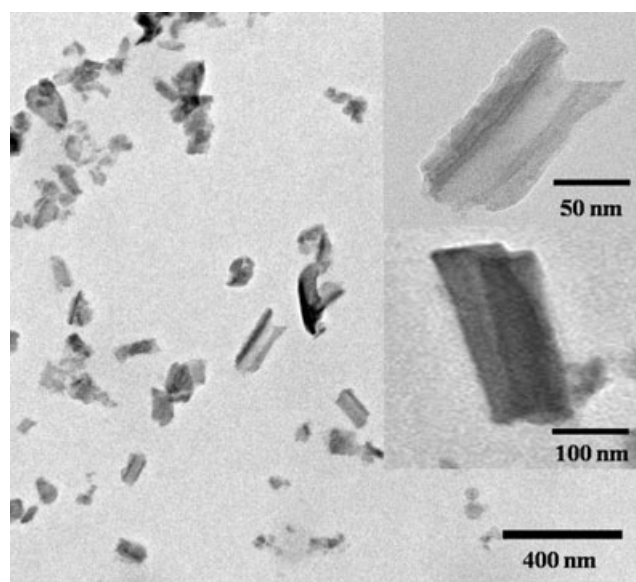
TEM image of the TiO₂ NT fragments with sizes ≤ 220 nm prepared by ultrasonication and filtration through a 220 nm microfilter.
